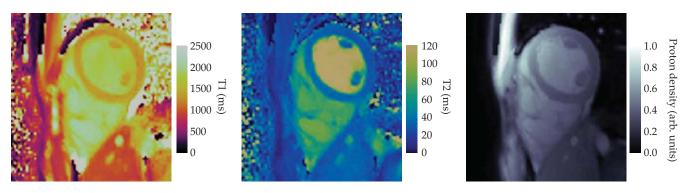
MAGNETIC RESONANCE FINGERPRINTING. In this image of a human heart, the technique provides quantitative maps of T1, T2, and proton density. All three images come from a single scan, whereas conventional MRI would require at least three separate scans to collect the same information. Clinical MRF research is underway to measure the effect of diseases and injuries on the three parameters. (Courtesy of Nicole Seiberlich, University of Michigan.)
